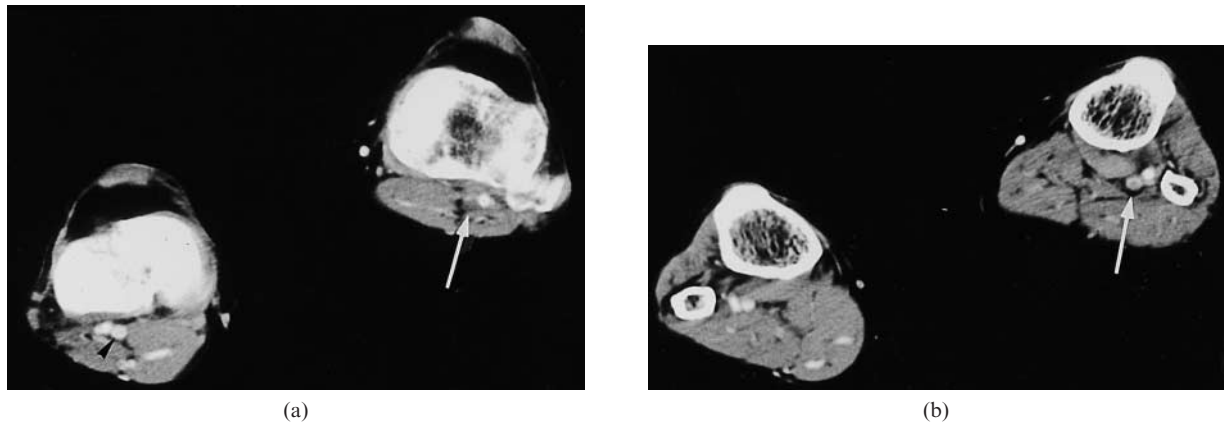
Deep vein thrombosis of the left popliteal vein in a 54-year-old woman with unilateral leg swelling, later confirmed by ultrasound. (a) CT axial image at knee level shows non-opacification of the left popliteal vein (arrow). The right popliteal vein is normal (arrow head). (b) CT axial image 3.0 cm caudal to (a) shows an intraluminal filling defect of the left popliteal vein without expansion (arrow).
